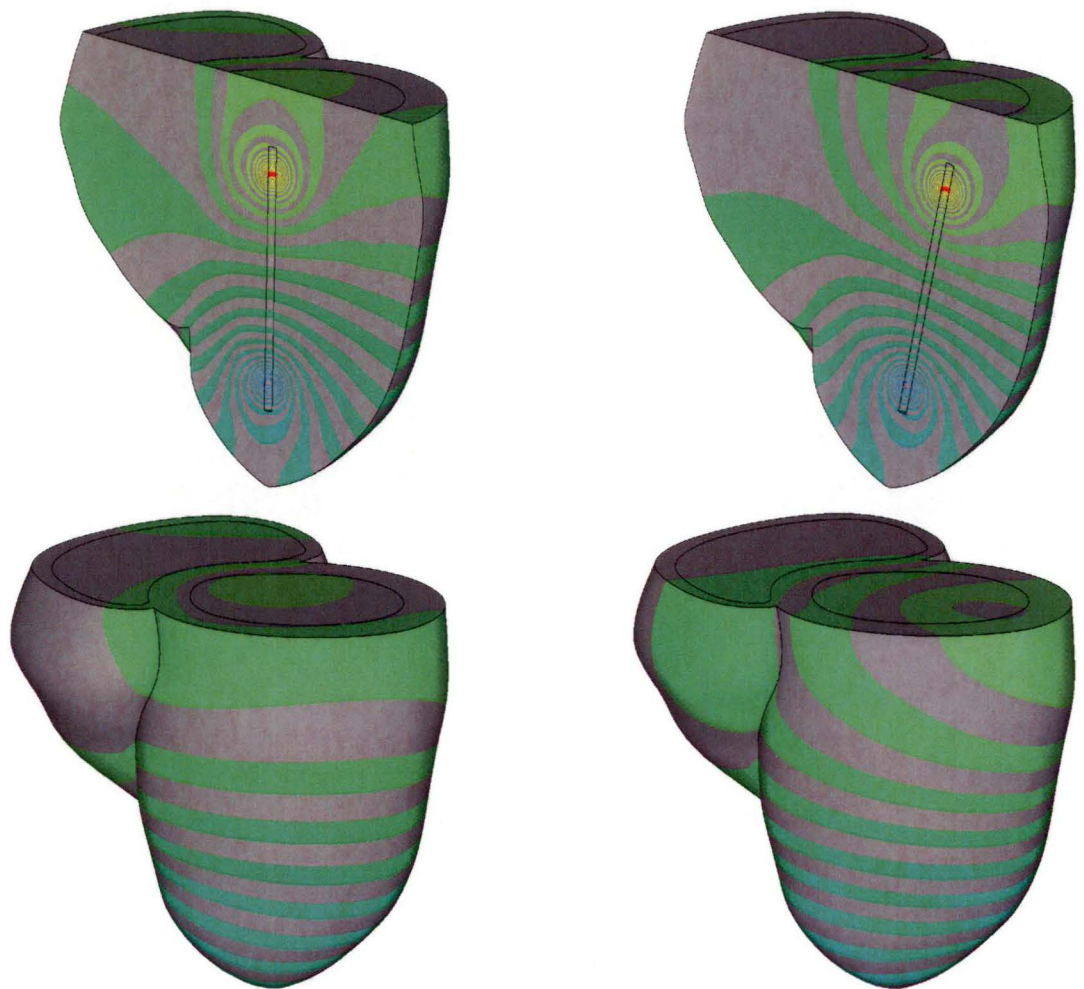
Off centre (septum - free wall direction) left ventricle catheter voltage contours in tagged MRI model at end diastole for blood conductivity/myocardium conductivity = 2.75.
